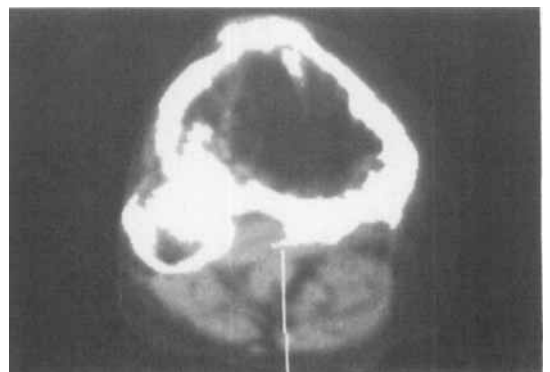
CT slice through the proximal tibia and fibula, with the computed pixels highlighted.
